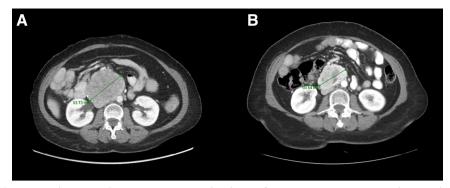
Computed tomography scans demonstrate tumor shrinkage of metastatic gastrointestinal stromal tumor, measured on axial image, on pexidartinib and binimetinib. Baseline image (A) and on-treatment image (B).
